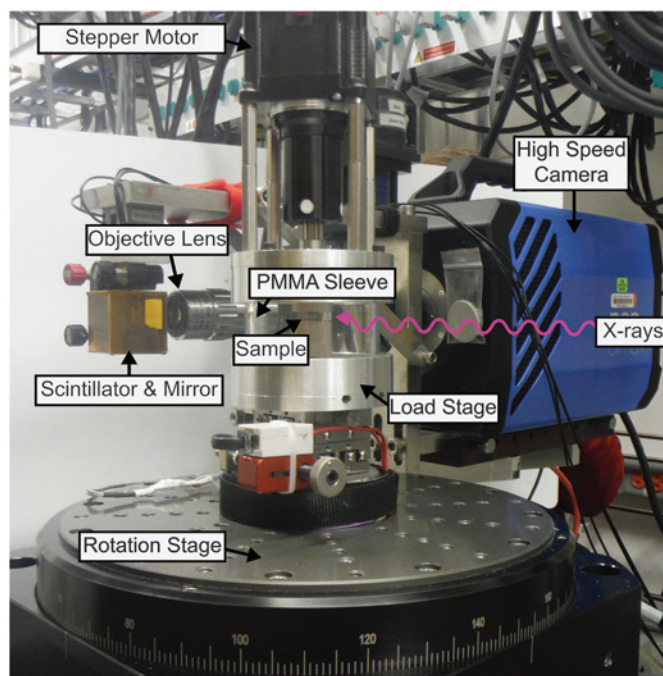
Photo of the loading stage and X-ray CT setup at the APS 2-BM beam line.
